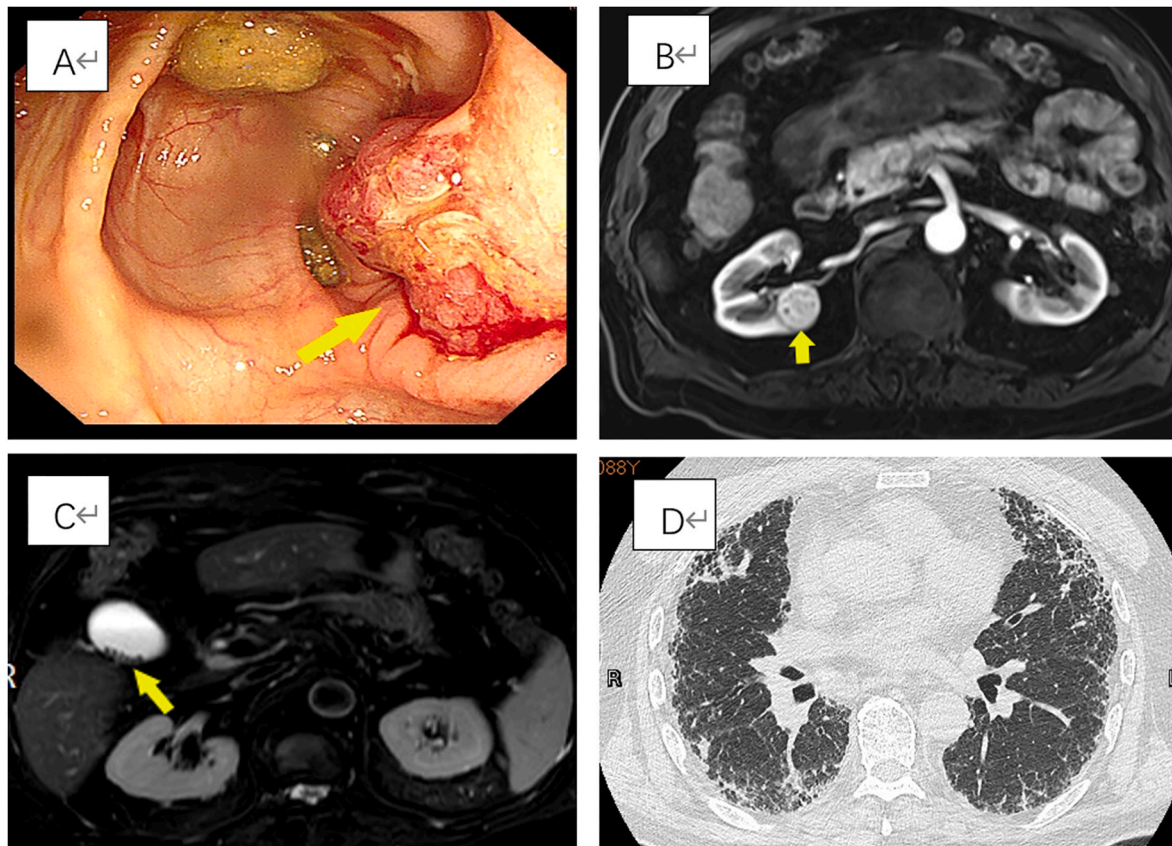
The examination images before the operation: A. Colonoscopy showed rectal cancer; B. Carcinoma of the kidney in abdominal MRI; C. gall bladder stones in abdominal MRI; D. Staging chest CT scan show servers chronic diffuse interstitial fibrosis of the lungs.).
